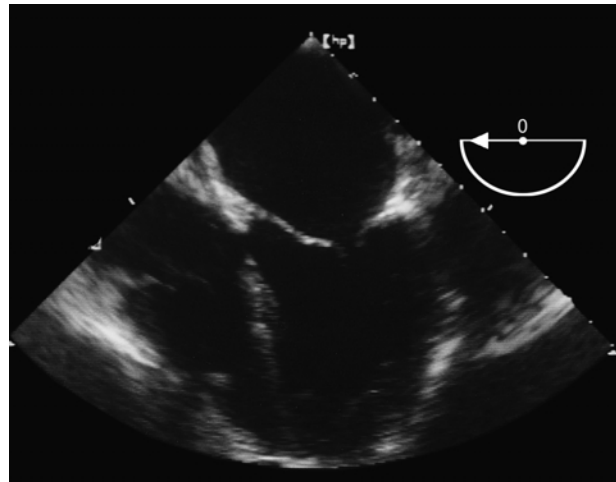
Transoesophageal four-chamber view.
